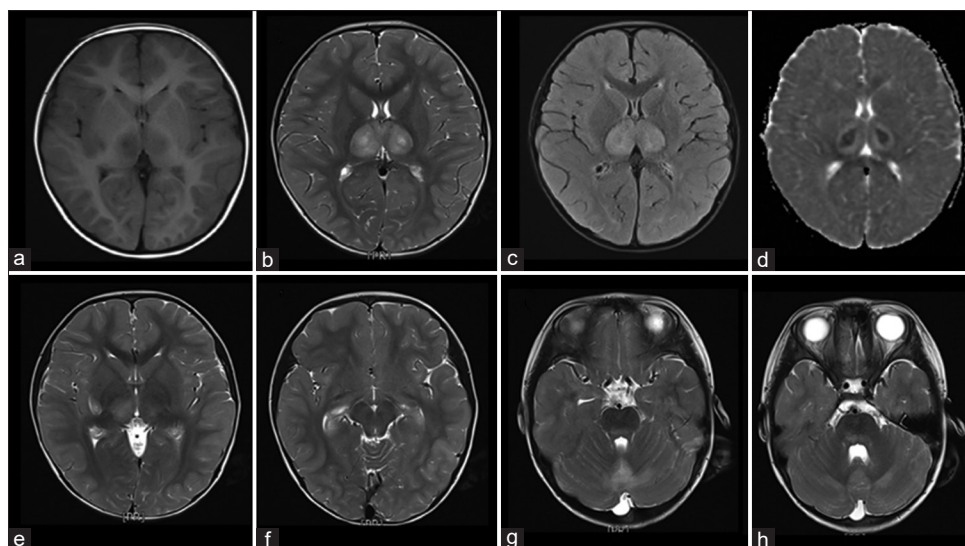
Axial T1WI, T2WI, T2-FLAIR, and ADC map on bilateral basal ganglia level. (a–d) Bilateral dorsal thalami are swollen with slight hypointensity on T1WI and slight hyperintensity on T2WI. Small nodules in the center of the lesions show a lower signal on T1WI and a higher signal on T2WI with slight hyperintensity on T2-FLAIR (c). Axial ADC map (d) shows a “dual-color pattern,” which indicates arterial, venous, and capillary congestion and cytotoxic edema of oligodendrocytes in the center of the lesion and peripheral exudation in the periphery of the lesion. Similar characteristic lesions are seen on the right putamen (e). (f–h) Slightly swollen and slightly hyperintense T2WI in the left temporal cortex, vermis, and bilateral cerebellar hemispheres, respectively. T1WI: T1 weighted image, T2WI: T2 weighted image, T2-FLAIR: T2 fluid attenuated inversion recovery, ADC: Apparent diffusion coefficient
